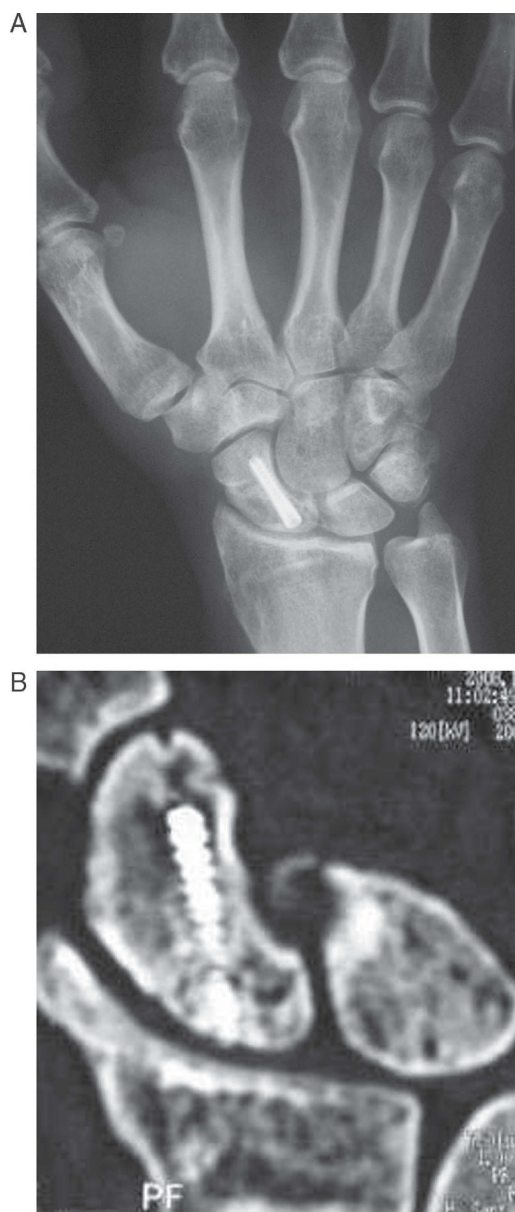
A) PA radiological projection. B) CT showing scaphoid consolidation after VBG in 1,2 ICSRA vessel.
